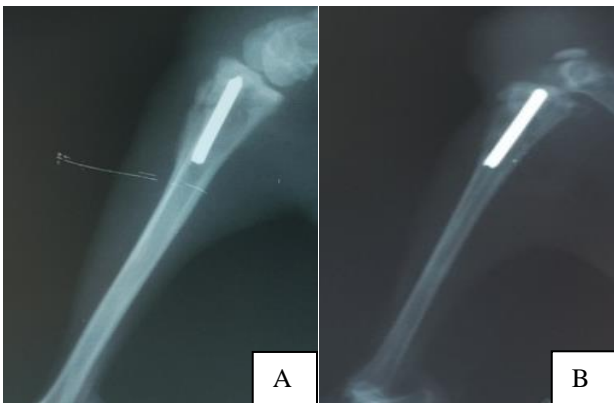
Radiography picture of chronic osteomyelitis; (A) Grade 3; (B) Grade 4.
